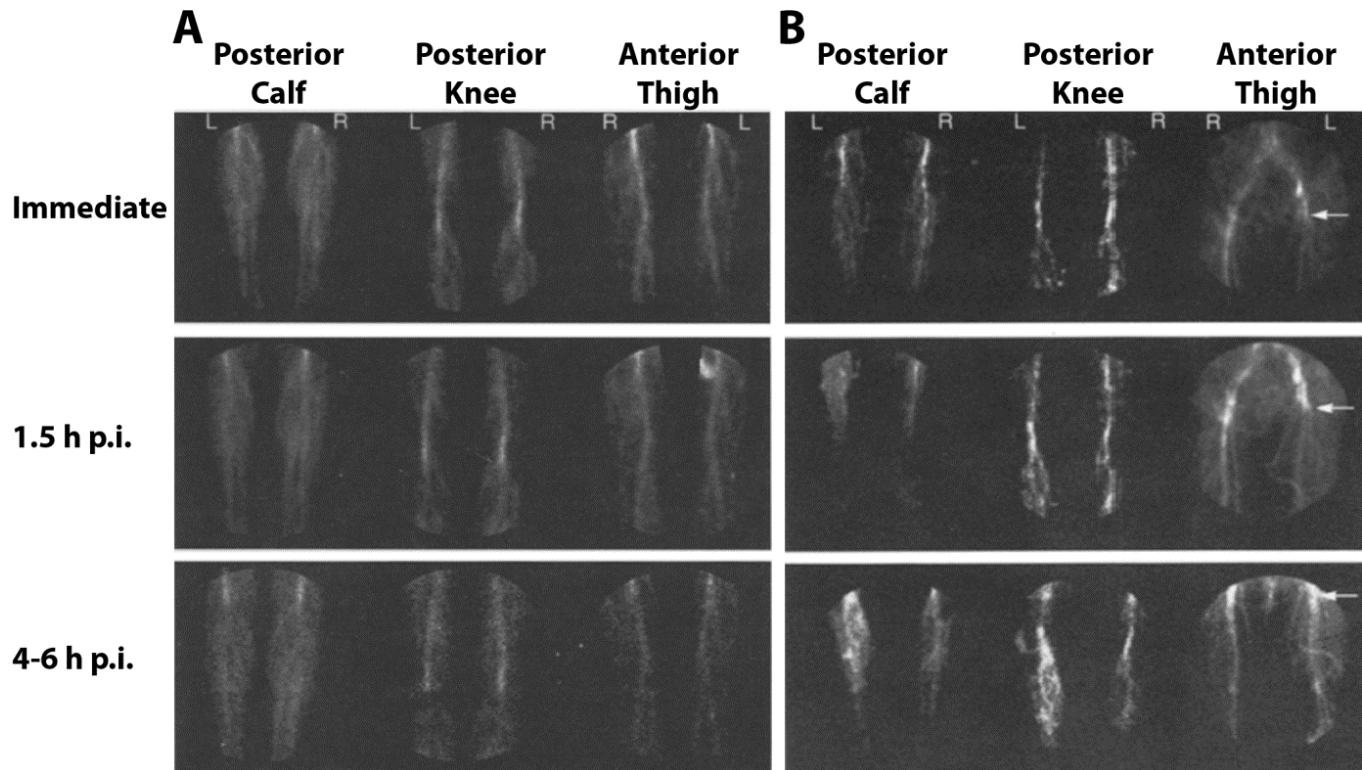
$^{99\text{m}}\text{Tc}$ -T2G1s Fab' scintigraphy of the legs immediately, 1.5 h and 4-6 h PI. (A) Low radiotracer uptake in legs without thrombosis. (B) Scintigraphic images of a case evaluated as positive for acute DVT in the left calf, knee and thigh region (white arrow). Reprinted from Manspeaker *et al.* with permission from Elsevier.¹³⁸
